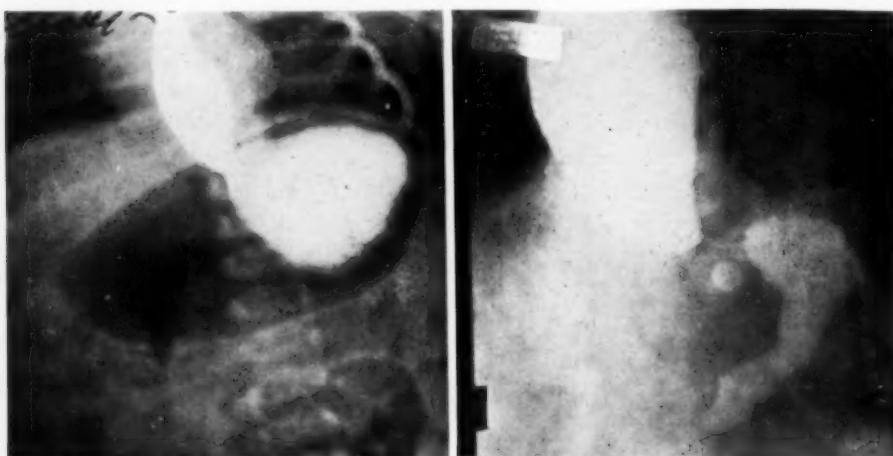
X-ray of infant which shows the opaque meal has entered the first part of stomach. Normal cardiac orifice dilated oesophagus. The meal was immediately rejected by a violent contraction of oesophagus.
